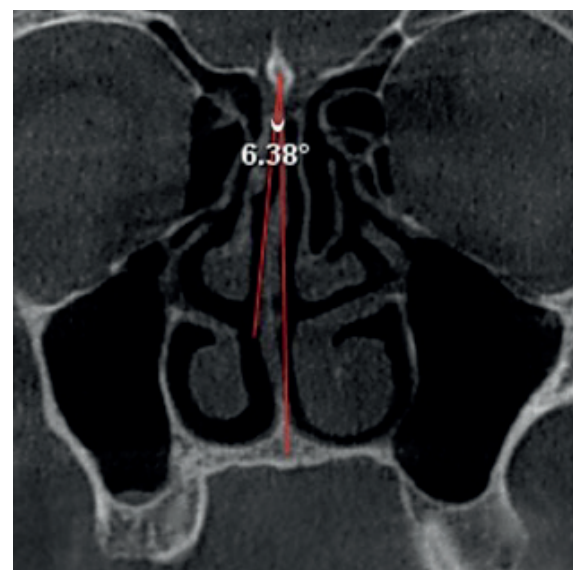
Measurement of nasal septum deviation angle in CBCT coronal section.
